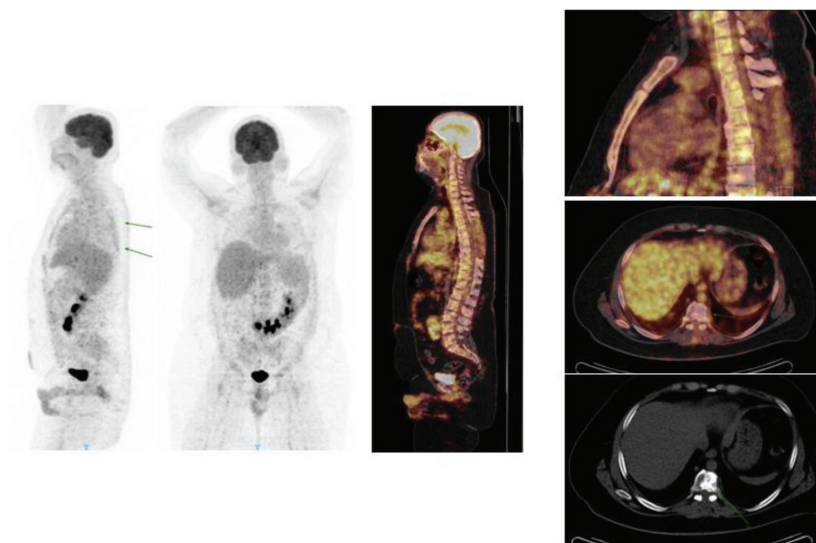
PET/CT scan on 7 Jan 2021 after Hyper CVAD chemotherapy and non-myeloablative stem cell transplantation (NMSCT) showed no significant change of residual left paravertebral mass adjacent to T7, 8 vertebral bodies, 0.9 cm in diameter, SUVmax =3.03 (previous 1 cm SUVmax=2.86, initially 1.8 cm thick, SUVmax= 15.9); complete metabolic response, Score II and osteoblastic lesion in the T8 vertebral body shows no FDG avidity, SUVmax= 2.24 (previous SUVmax=3.64), same as normal vertebra; post treatment change of bone involvement (complete metabolic response)
